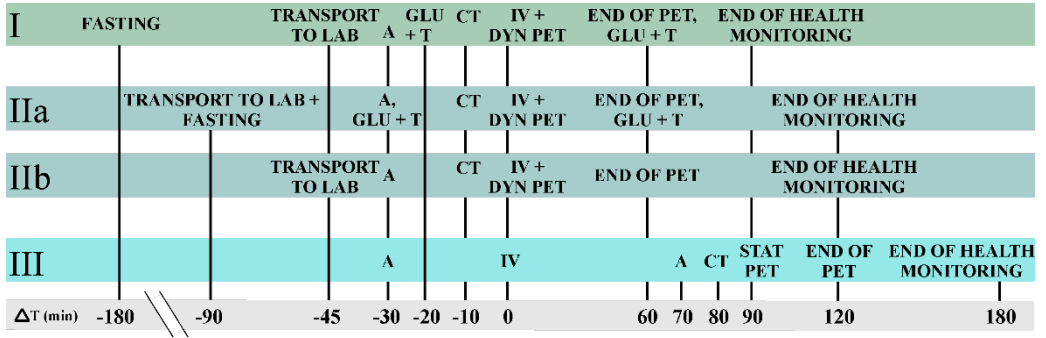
In vivo* PET imaging work flow for studies I-III in accordance to the tracer injection time at 0. ^{18}F -FDG was used in studies I and IIa, whereas ^{18}F -DPA-714 was used in IIb. For Study III, ^{18}F -FMPEP- d_2 was utilized for PET imaging. *A*, anesthesia; *CT*, computed tomography; *dyn*, dynamic; *GLU*, glucose; *IV*, intravenous injection of the tracer; *PET*, positron emission tomography; *stat*, static; *T*, body temperature.
